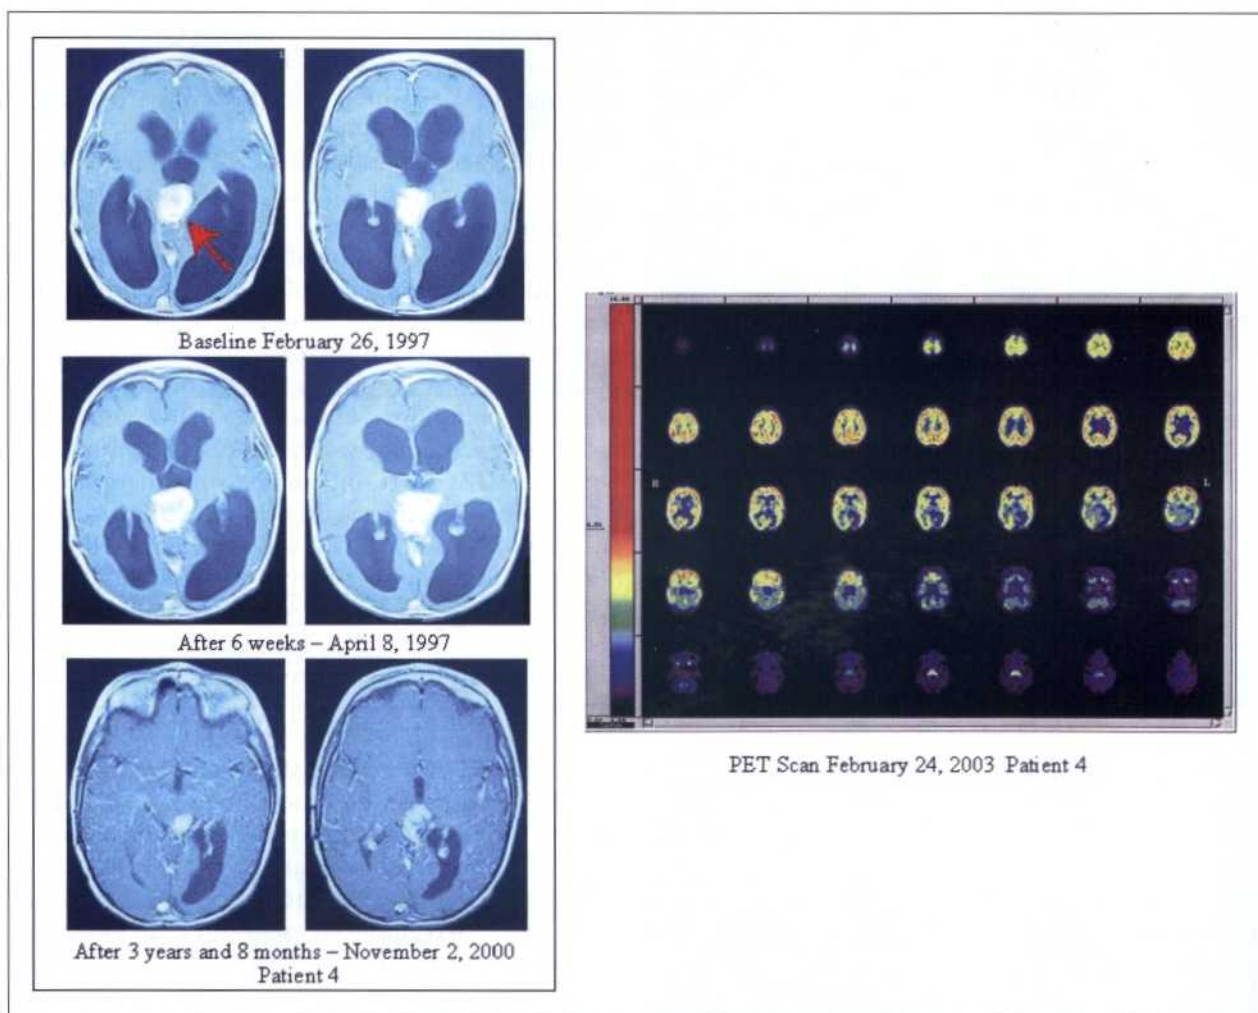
Treatment of a 1-year-old girl with pineoblastoma (patient 4). The patient's tumor progressed after partial resection and was not treated with radiation and chemotherapy. T1-weighted gadolinium magnetic resonance imaging of the head shows decrease of the tumor size (left). Positron emission tomography (PET) scan confirms complete response (right). The patient has been living a normal life for 7½ years since initiation of antineoplastons.
